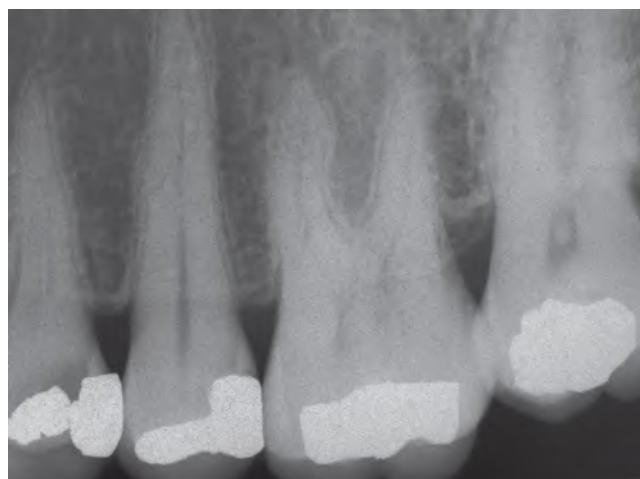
Periapical radiograph of a maxillary left molar in a 46-year-old female. The patient received a direct pulp cap in the second molar with hard setting calcium hydroxide (Dycal®) approximately 10 years before. The molar exhibited a delayed response to cold testing. Dystrophic calcification can be seen including a large pulp stone.
